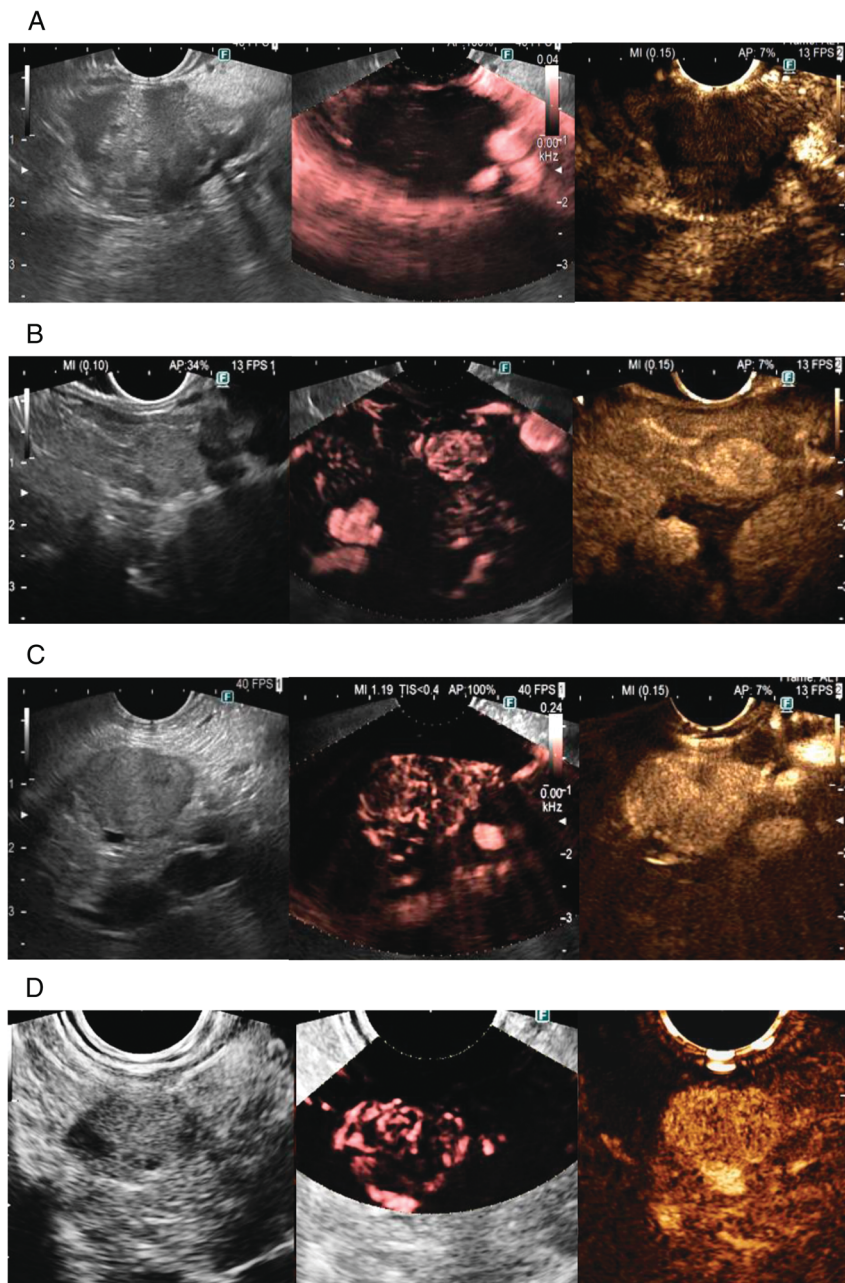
Examples of endosonographic images showing pancreatic lesions, from the left to the right, in B-mode, DFI-EUS, and CE-EUS. (A) A case of pancreatic adenocarcinoma. (B) A case of neuroendocrine tumor. (C) A case of pancreatic metastasis. (D) A case of accessory spleen. CE-EUS: contrast-enhanced EUS; DFI-EUS: detective flow imaging EUS.
